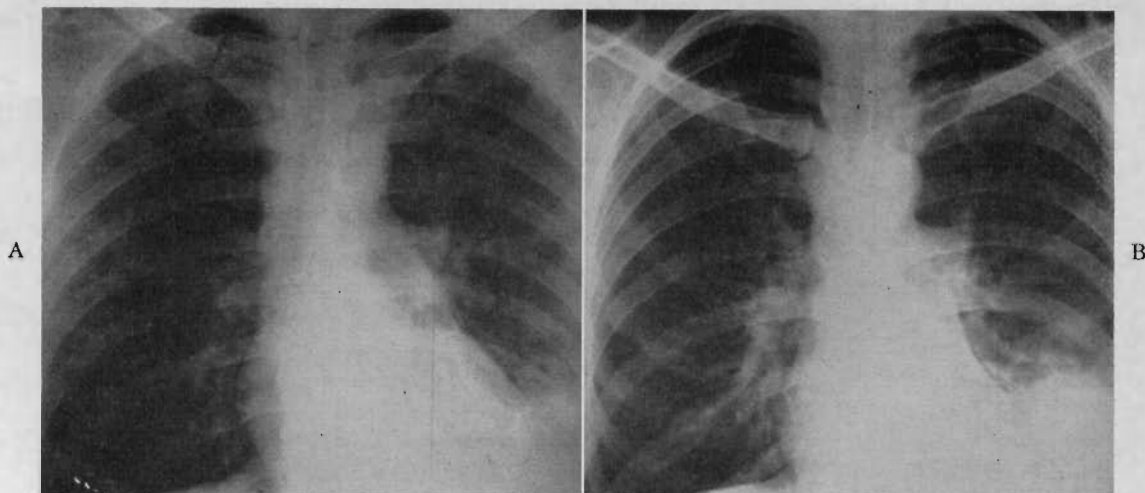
Roentgenogram of chest (Case III): A, at admission, and B, three weeks later. Note increase in size of density.
